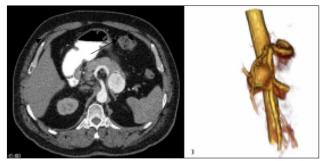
CT angiography and reconstruction of a splenic artery aneurysm.
